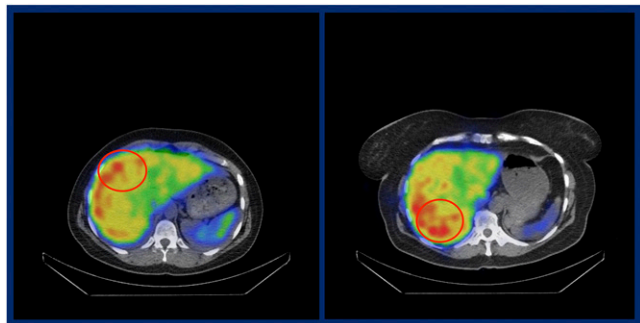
^{99m}Tc -tilmanocept in SPECT/CT imaging of activated macrophage infiltration in metastatic liver colorectal adenocarcinoma. Fused SPECT/CT images acquired 4–6 hours after ^{99m}Tc -tilmanocept injection in 2 patients shows the presence of tumor-associated macrophage populations (CD206+ macrophages) around metastases (red circles).
